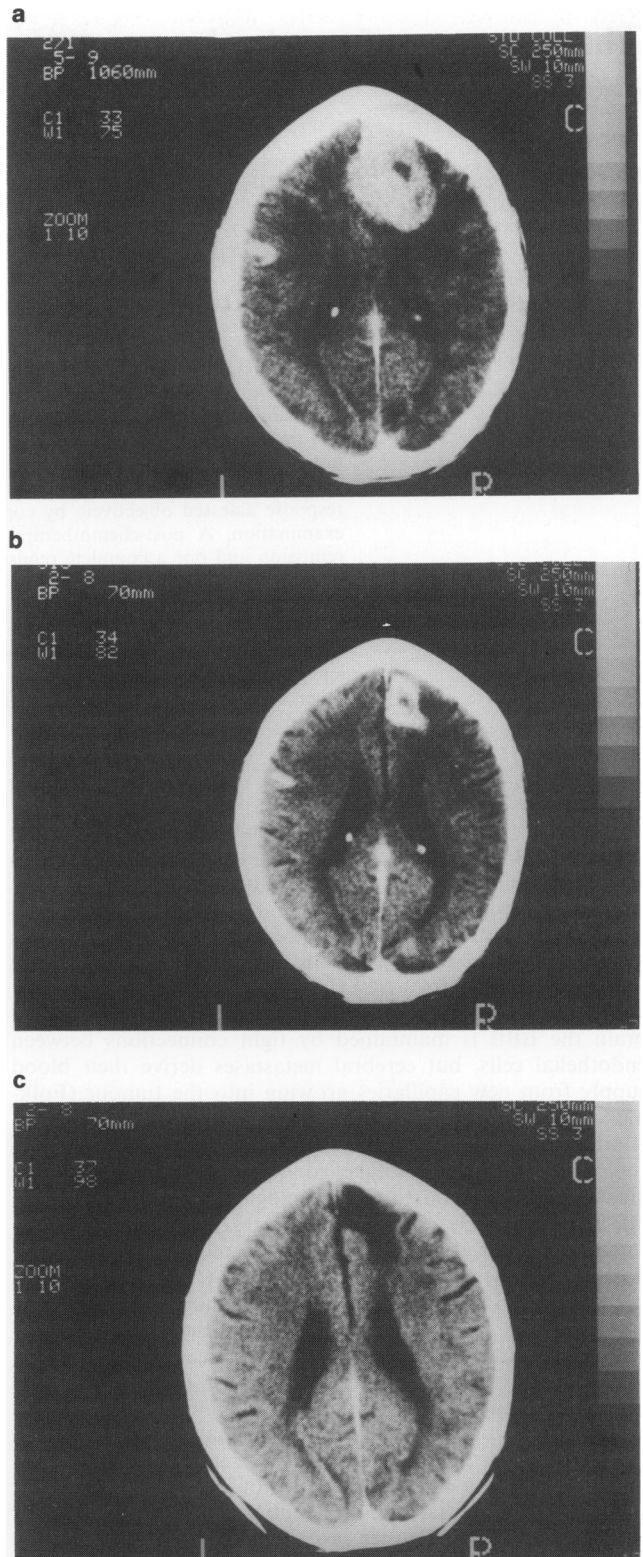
Enhanced CT brain scan (a) before chemotherapy, (b) after one cycle and (c) after four cycles of chemotherapy.
